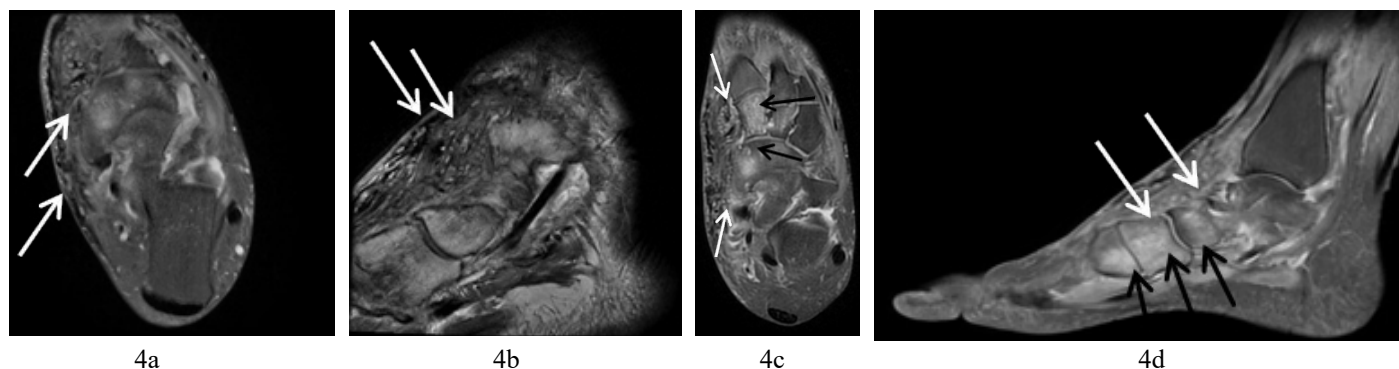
MRI images of Mycetoma. FINDINGS: FS-PDWI axial (4a) and T2WI sagittal (4b) ankle images show multiple round and nodular hyperintense lesions with a central hypointense dot and a peripheral rim of low signal intensity (“dot-in-circle” sign) (white arrow) of subcutaneous tissue, muscles, neurovascular bundles, tendons and bones. FS-PDWI axial foot image (4c) represents bone erosion and destruction with diffuse marrow edema and “dot-in-circle” sign in multiple bones especially the medial cuneiform and navicular bone (black arrow) , as well as deep subcutaneous tissue lesions of medial foot (white arrow) . FS-PDWI sagittal foot image (4d) demonstrates more advanced erosive destruction and tubular changes in many tarsal bones (black arrow) and the first metatarsal bone as well as generalized deep subcutaneous tissue lesions of the dorsal foot (white arrow). TECHNIQUE: GE SIGNA Architect 3.0T; 4a: FS-PDWI axial TR=3200ms, TE=40ms. 4b: T2WI sagittal TR=5200ms, TE=100ms. 4c: FS-PDWI axial TR=2800ms, TE=40ms. 4d: FS-PDWI sagittal TR=2800ms, TE=40ms. 3mm slice thickness.
